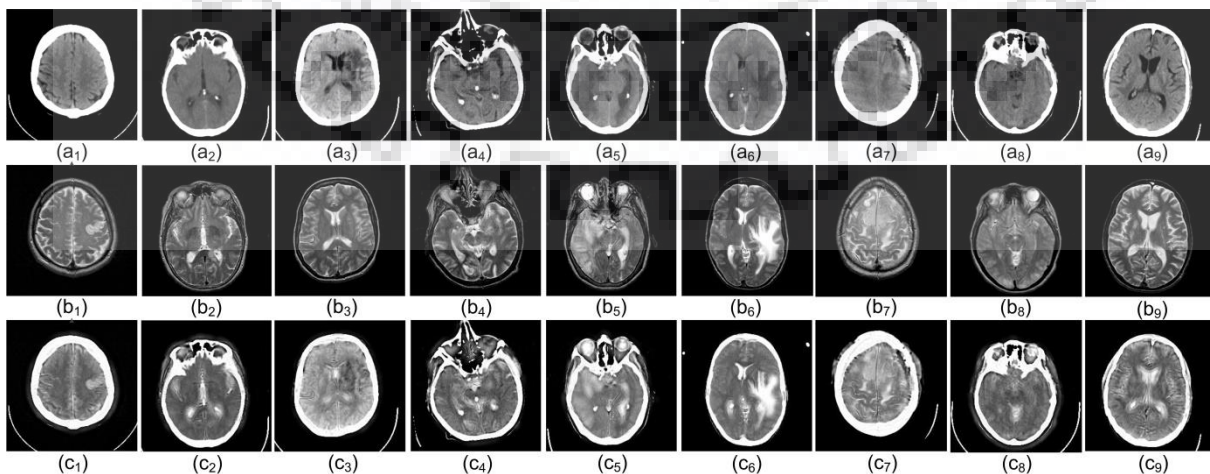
(a) Source CT images, (b) MR images (c) Fused images obtained by the proposed NSST-MIF approach
